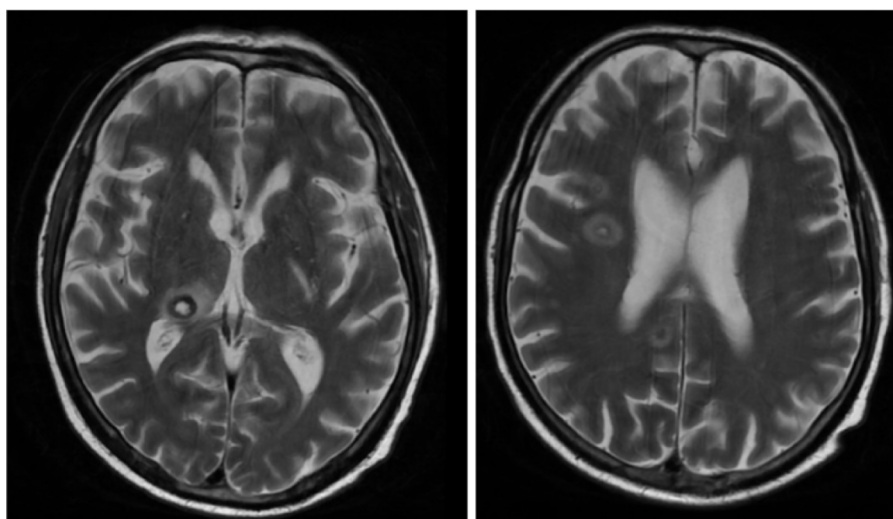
Brain MRI. At least 13 intra-axial lesions were detected with a rounded morphology located in both cerebral hemispheres with a hyperintense halo.
